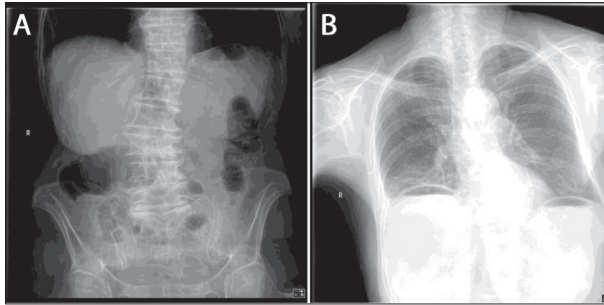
Abdominal (A) and chest (B) X-ray
